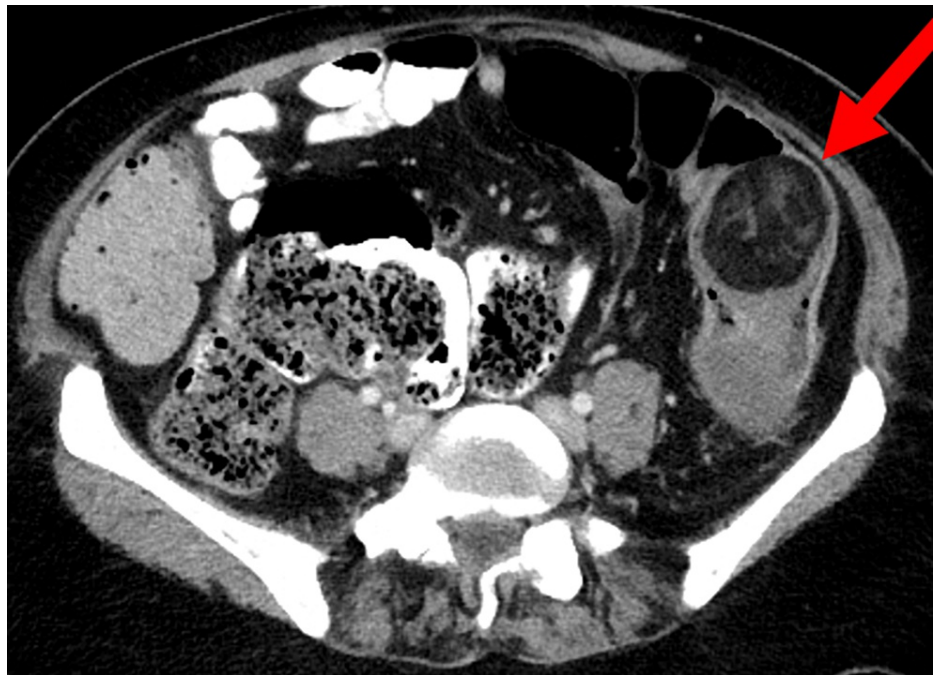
Axial CT scan showing lipoma
